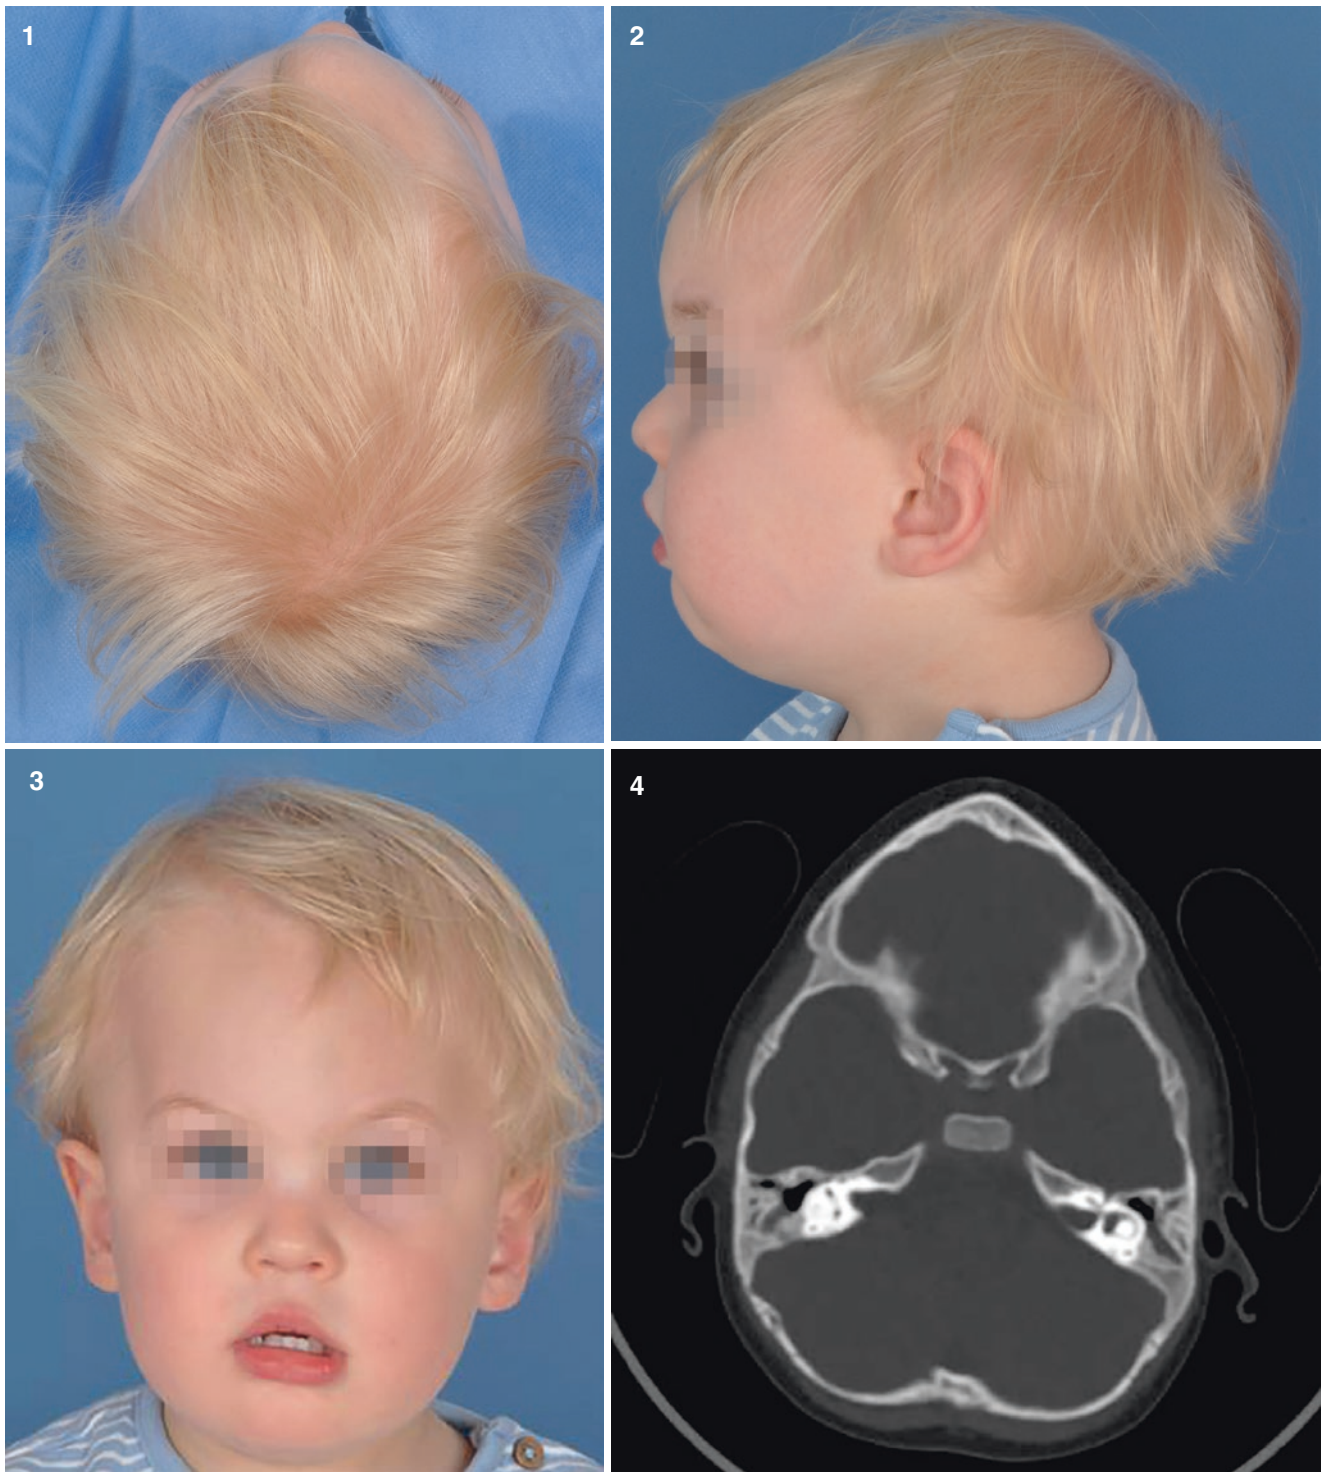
(3.1–3.17) Case series of metopic synostosis. (3.1–3.3) Preoperative facial views of patient with metopic synostosis, age 23 months (late presentation), note pointed brow, triangular-shaped skull and hypertelorism. (3.4–3.6) Preoperative CT scan of the same patient with metopic synostosis—note it is not our usual practice to obtain preoperative CT in metopic synostosis; however this was taken due to the subtle (and late) presentation. (3.7–3.14) Intraoperative views of fronto-orbital remodelling. (3.7) Frontal bar after removal prior to remodelling. (3.8) Frontal bar and frontal bones after removal
